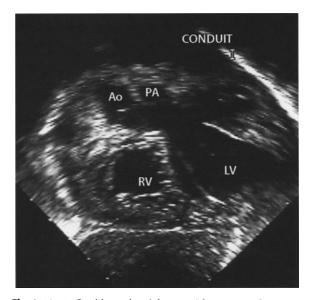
Double outlet right ventricle: surgery. Postoperative echocardiography of the same patient as in Fig. 2.11.7 showing the relationship between the tunnel left ventricle-aorta and the biological valved conduit implanted between the right ventricle and pulmonary artery (*Ao* aorta, *LV* left ventricle, *PA* pulmonary artery, *RV* right ventricle)
